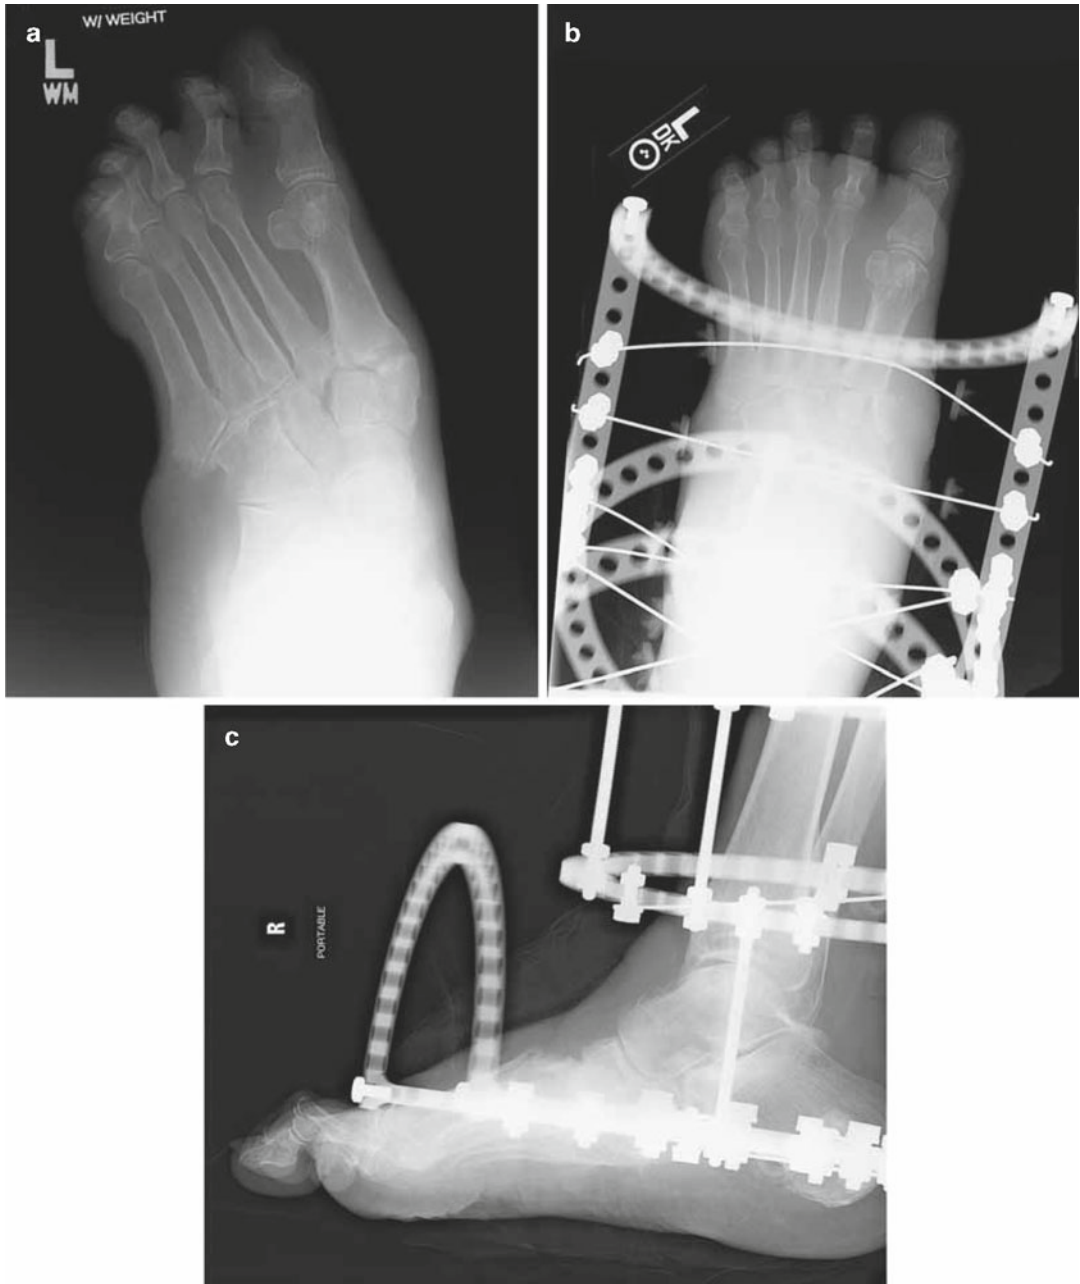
(a) This patient has a chronic midfoot ulcer associated with a rocker-bottom deformity. (b) Radiograph of same patient showing severe rearfoot equinus and mid-foot deformity
